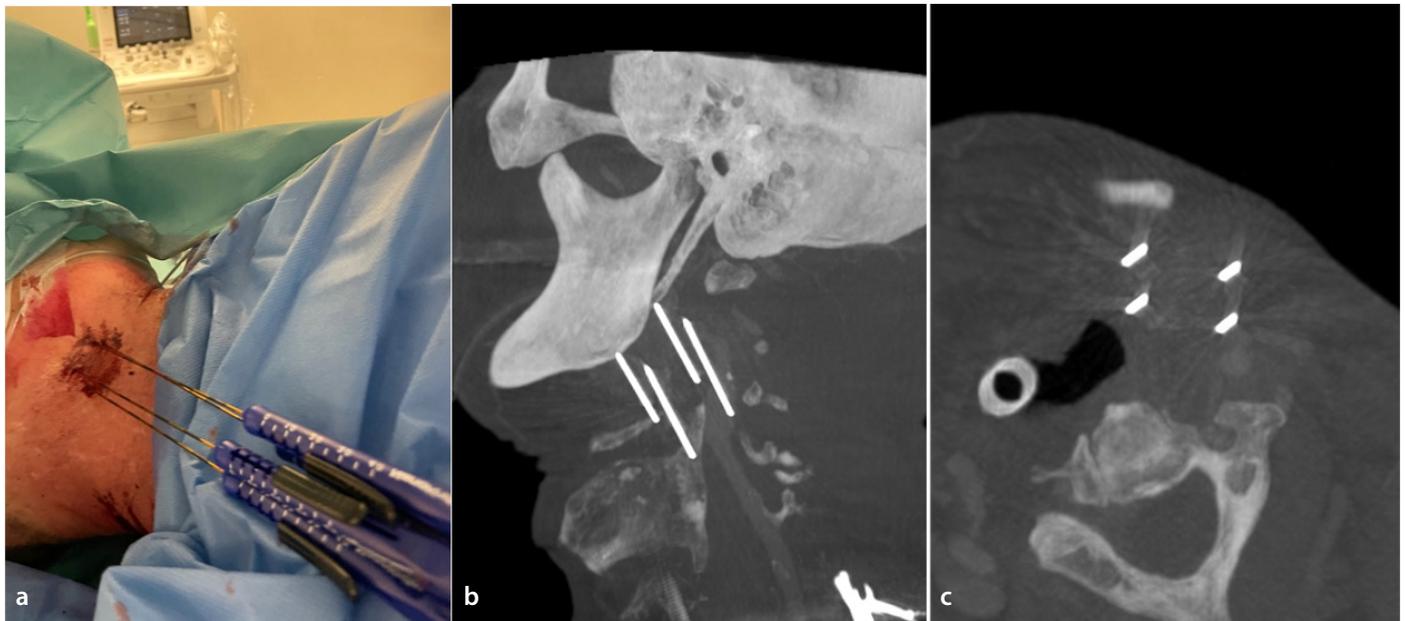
Final position of the needles (a). Intra-procedural control cone-beam computed tomography (b and c) confirms accurate parallelism and distances between electrodes.
